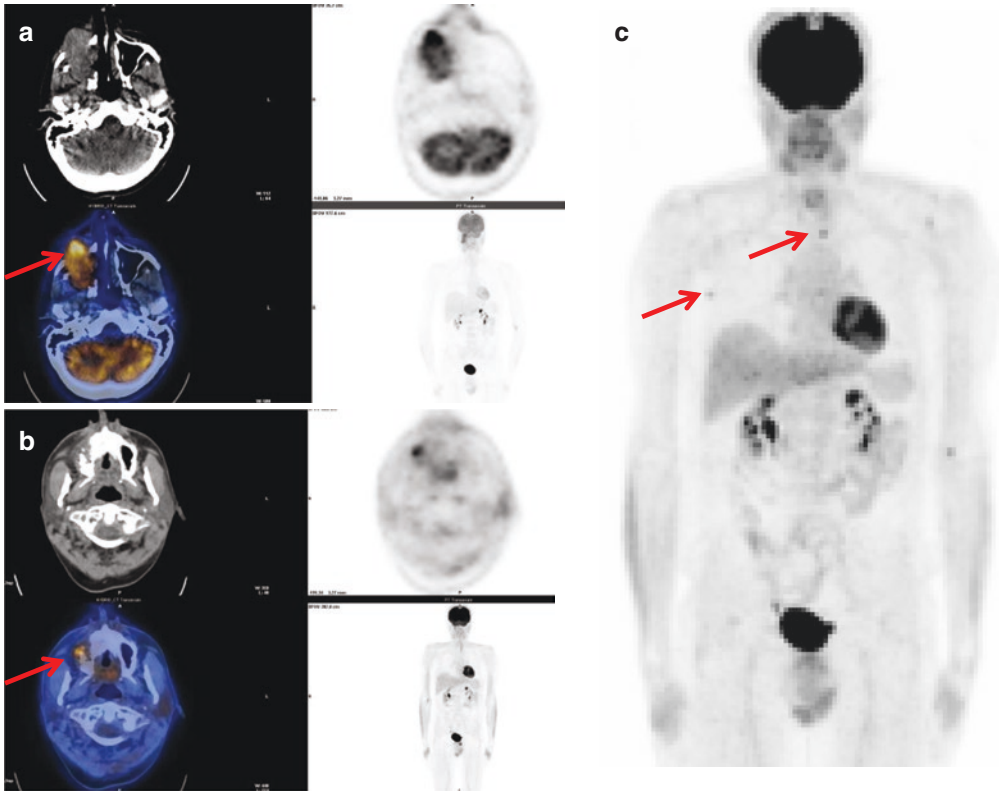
A 74-year-old female with malignant melanoma. (a) FDG PET/CT performed at the end of therapy showing the persistence of 3 bone hypermetabolic focal lesions despite a clinical complete response. (b) Still positive but stable PET/CT during the maintenance therapy. Focal lesions were radiotreated. (c) Negative FDG PET/
